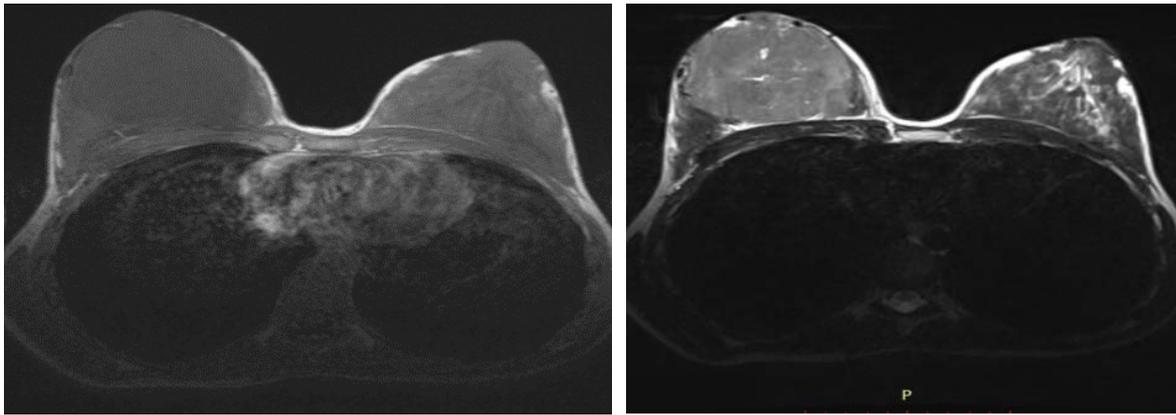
MRI T1 and T2 axial sequences suggesting tumor aspects without contrast agent.
